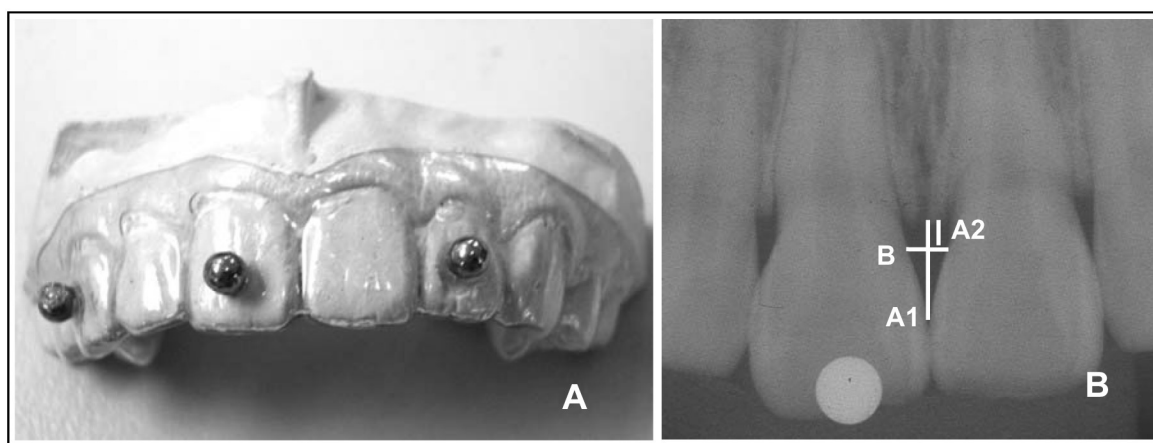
A. The plastic stent with the metal balls diameter 3.17 mm; B. Radiographic image of maxillary anterior teeth; A1 = the vertical distance from the contact point to the crest of bone, A2 = the vertical distance from the crest of bone to CEJ, B = the horizontal distance between the adjacent CEJs.
